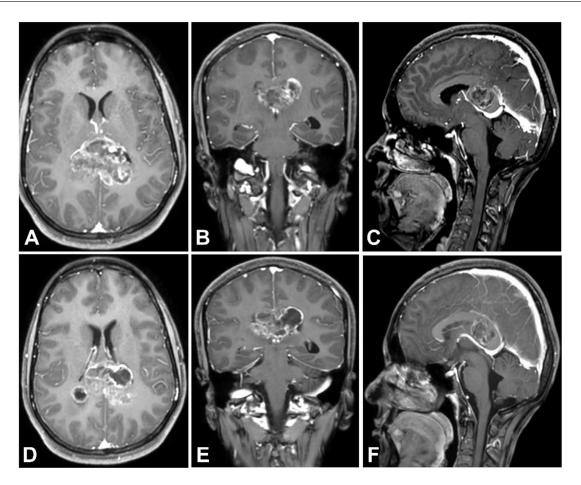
Axial, coronal, and sagittal MRI T1+C sections highlighting a heterogeneously enhancing lesion in the splenium of the corpus callosum, causing effacement of the occipital horns of the bilateral lateral ventricles and the third ventricle.
